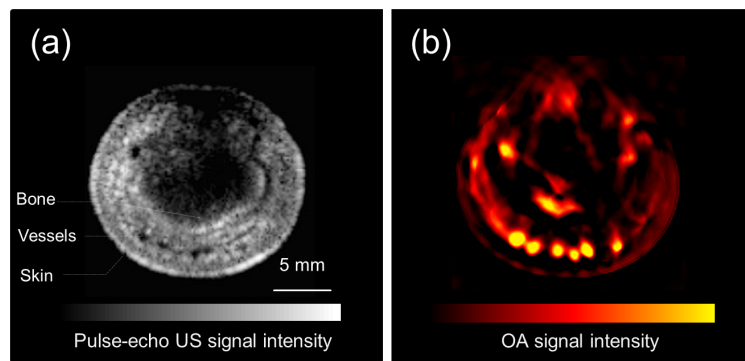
OAT and pulse-echo US images of a human proximal interphalangeal joint in transverse plane. (a) Ultrasound image, with indicated anatomical structures, acquired with concave array with 270° angular coverage and pitch size of 0.37 mm; (b) The corresponding OA image acquired with the same array.
